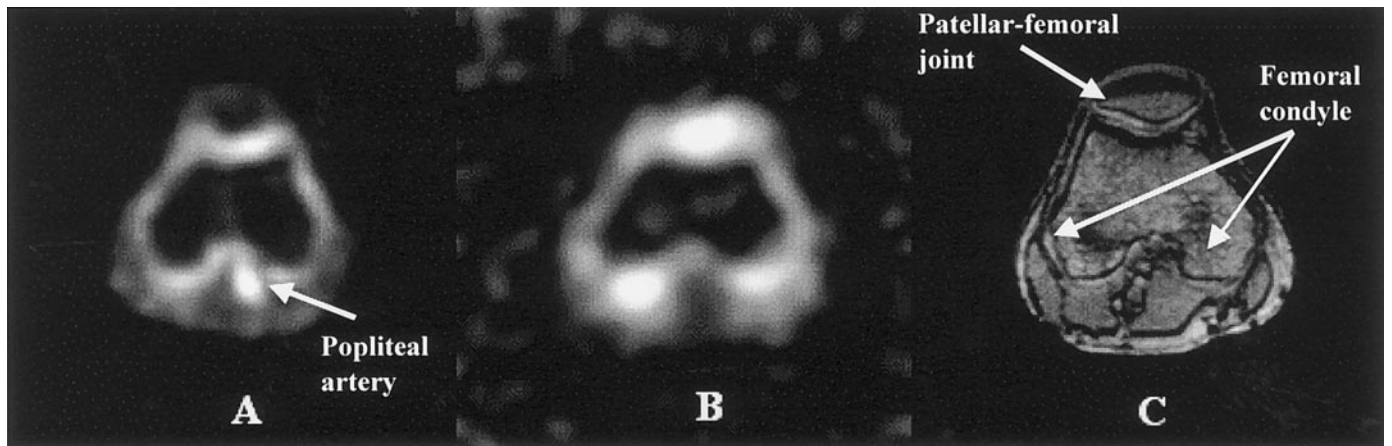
In vivo* sodium (A) single quantum and (B) TQF axial MR images across the human knee of a healthy 27-year-old male volunteer. C is the corresponding proton image of the same location. In the single quantum image (A), the arrow indicates an artery, which is not visible in the TQF image (B).
